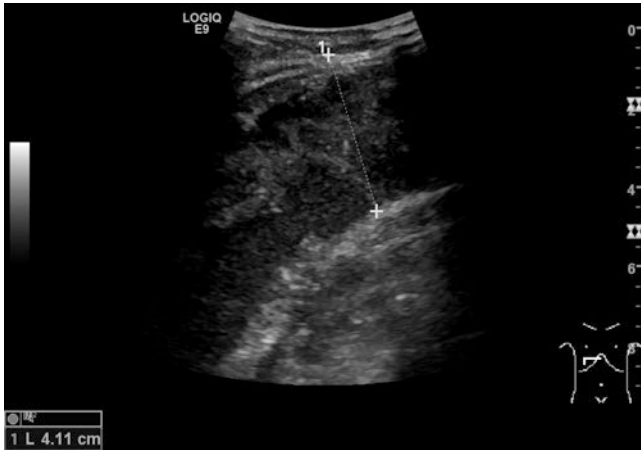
A 35-year-old man with diabetes, renal insufficiency and a history of drug addiction. Extended abscess in the soft tissue of the right ventral chest wall (markers) caused by an infected central venous line in the jugular vein. Microbiological analysis of sonography-guided aspiration revealed *Staphylococcus*
